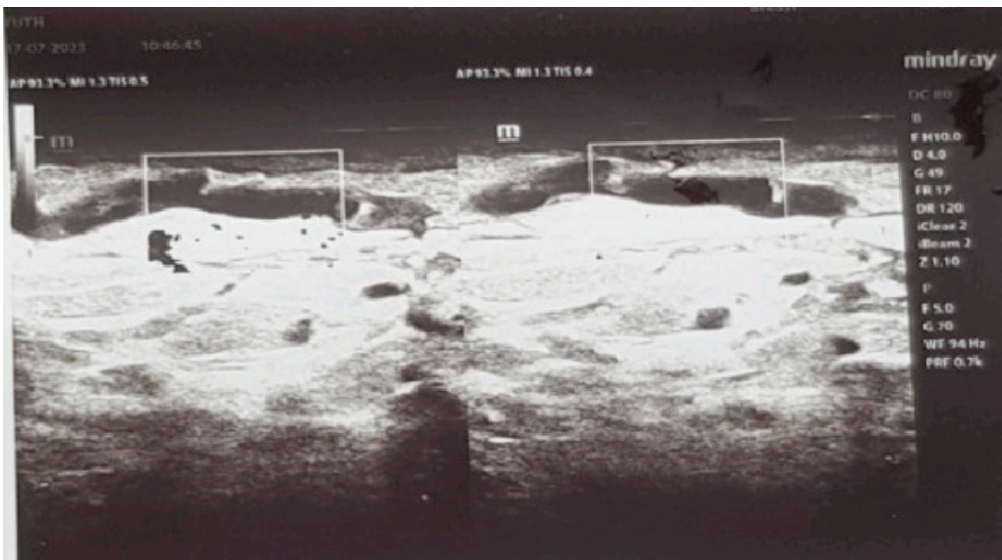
Color Doppler ultrasound showing no flow signal within the dilated vein
